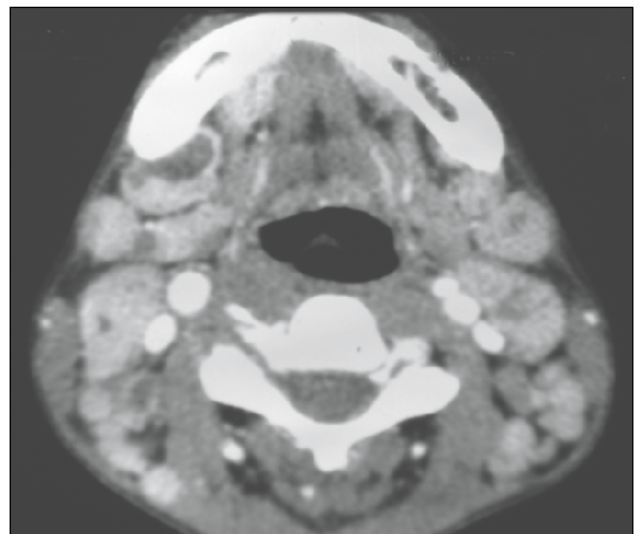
Axial CT scan through upper neck demonstrating lymph nodes adjacent to great vessels.
